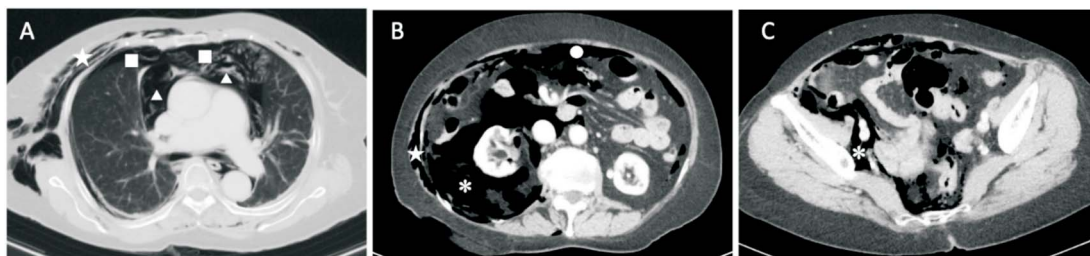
CT scan from the chest to the pelvis revealing pneumomediastinum (marked as ▲) and bilateral pneumothorax (marked as ■) in the chest (panel A). Extensive subcutaneous emphysema (marked as ★) was observed from the neck to the trunk (panels A and B). Diffuse pneumoperitoneum (marked as ●) associated with right-side pneumoretroperitoneum (marked as *) was observed in the abdominal cavity (panels B and C).
